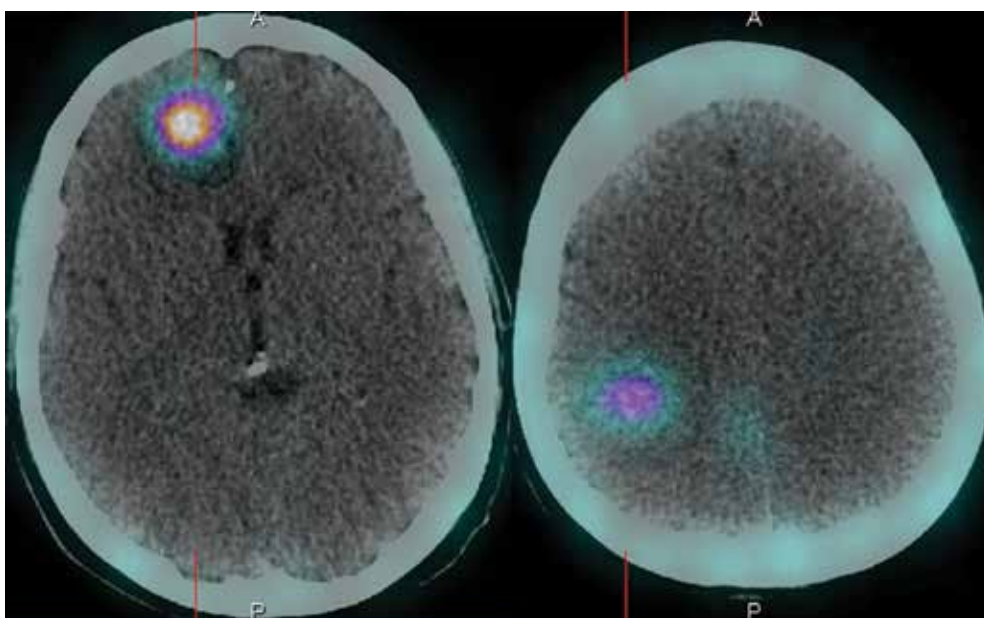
A 43-year-old female with neuroendocrine carcinoma of unknown primary site (case number 2). ^{99m}Tc -EDDA/HYNIC-TOC SPECT/CT didn't reveal primary tumor site. SPECT/CT (axial view) showed increased radiopharmaceutical uptake in frontal and parietal lobe. SPECT/CT, single photon emission computed tomography/computed tomography
